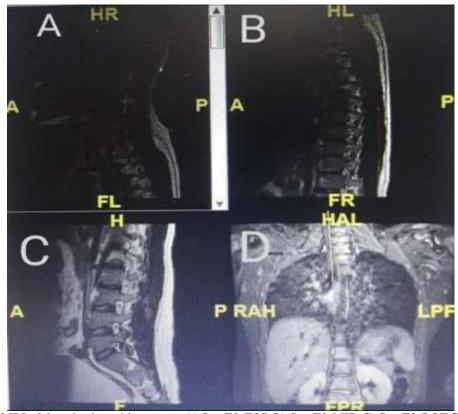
(a):- MRI of dorsal spine with contrast: A) Sag T2-TOP; B) Sag T2-MID; C) Sag T2-BOT; D) COR-STIR.
